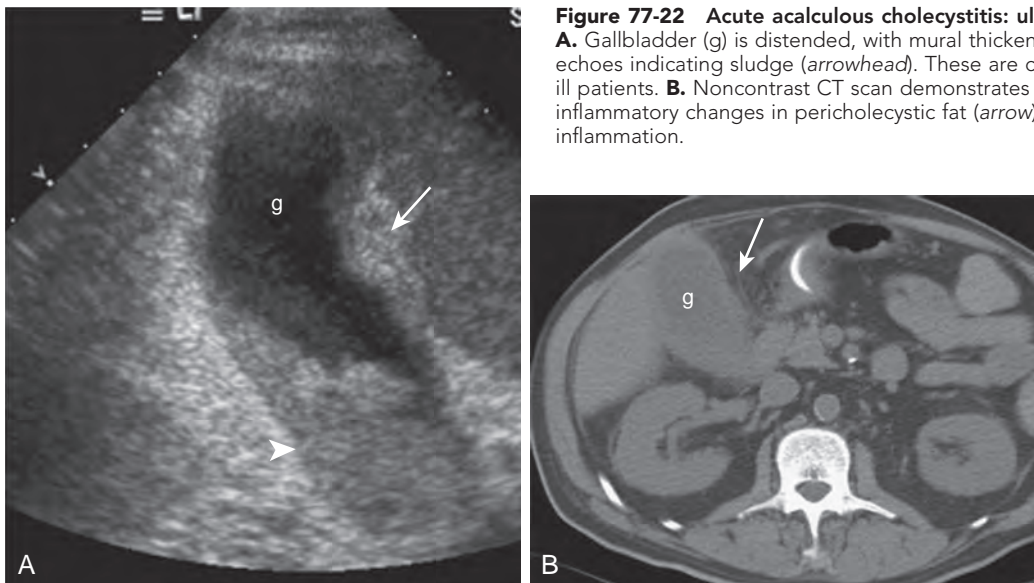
Acute acalculous cholecystitis: ultrasound and CT findings.
